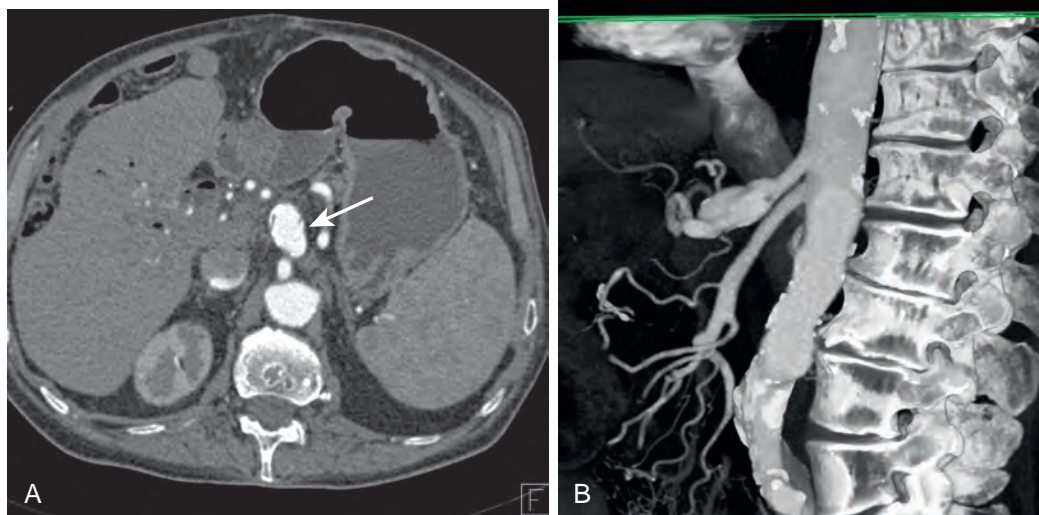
Celiac artery aneurysm. A. Axial contrast-enhanced CT image in the arterial phase demonstrates an aneurysm (arrow) of the celiac artery. B. Volume-rendered (VR) projection nicely demonstrates the complex shape of the celiac artery aneurysm, which begins approximately 1.5 cm distal to the origin of the celiac artery.
